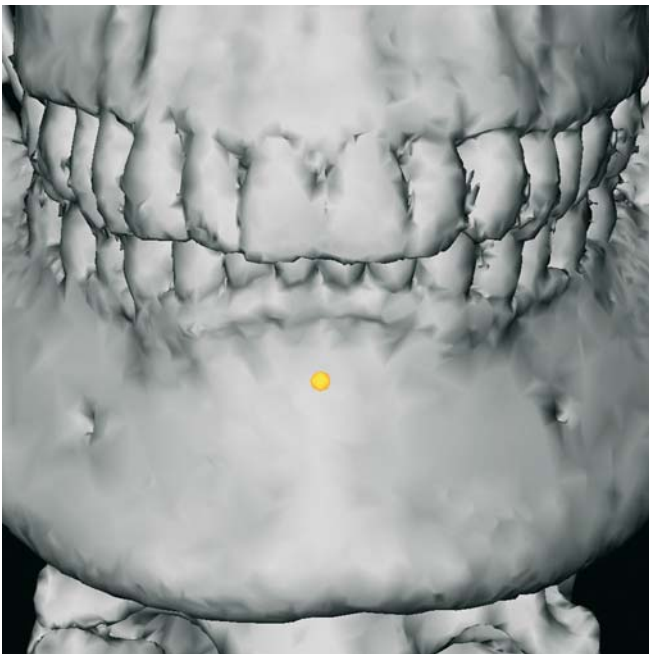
B-Point. Frontal view (3-D CT, patient K.C.)
